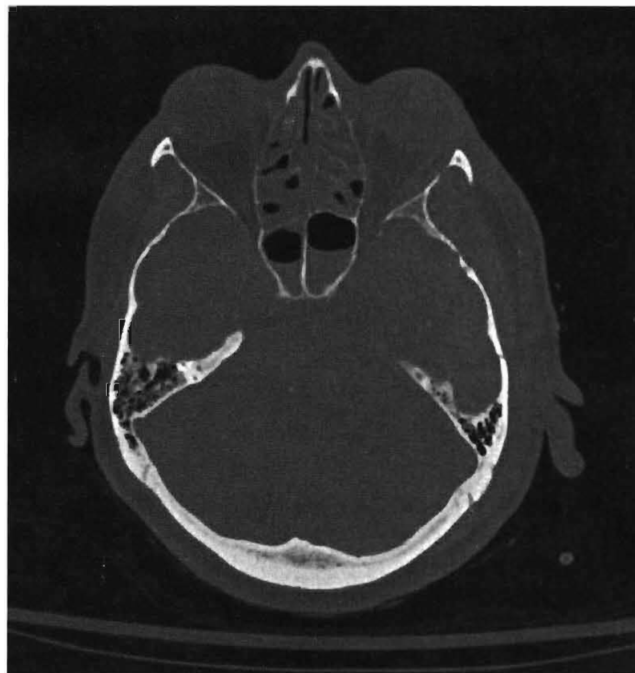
Basilar skull fractures through the anterior skull base typically cause cerebrospinal fluid rhinorrhea and tears in the adjacent dura. CT scans through the base of the skull may not show the fracture itself but often show fluid in the sphenoid sinus or the other paranasal sinuses (axial CT scan, bone window).
